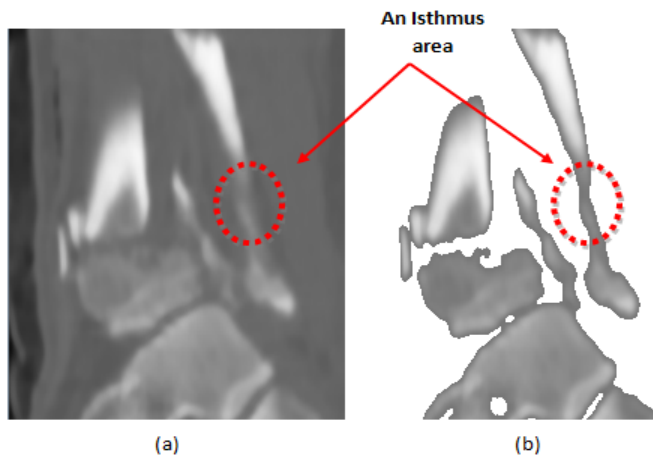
An example of an “isthmus” of bone area. (a) A CT image of a fractured bone. (b) An image of the estimated bone region. Circled area shows a location for an “isthmus” of bone area where two bone fragments are touching. An ”isthmus” area has a small width compared to other bone region areas.
